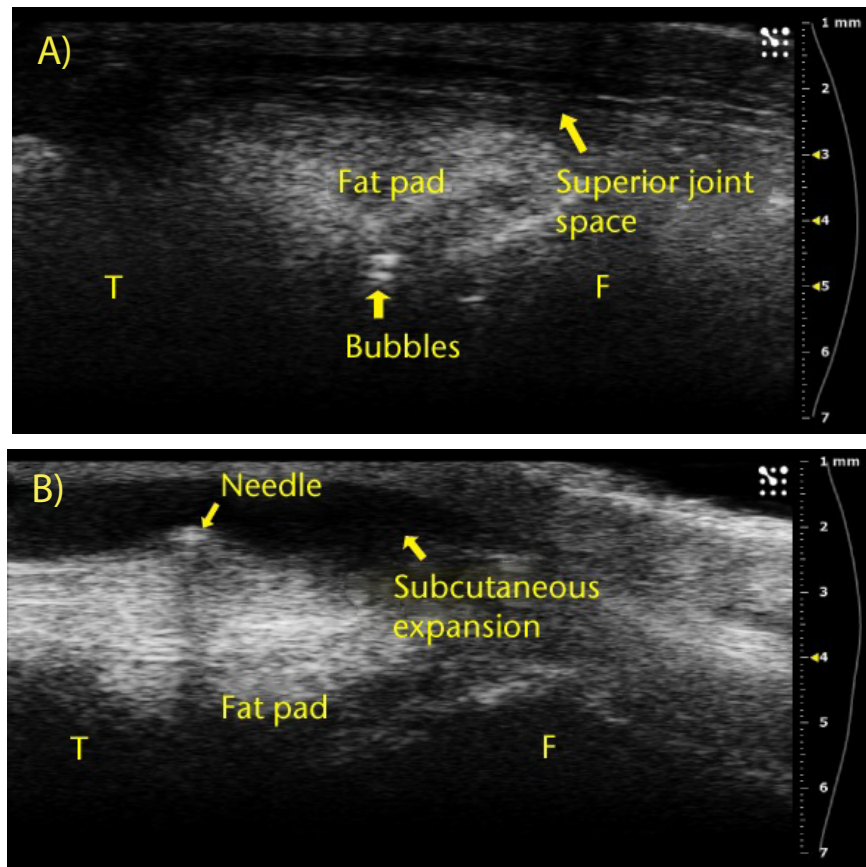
Ultrasound images showing (A) that bubbles helped visualize the injections and were clearly observed in the joint space between femur and fat pad. The needle (B) and subsequent metal shadow are clearly seen during an injection that created subcutaneous expansion.
